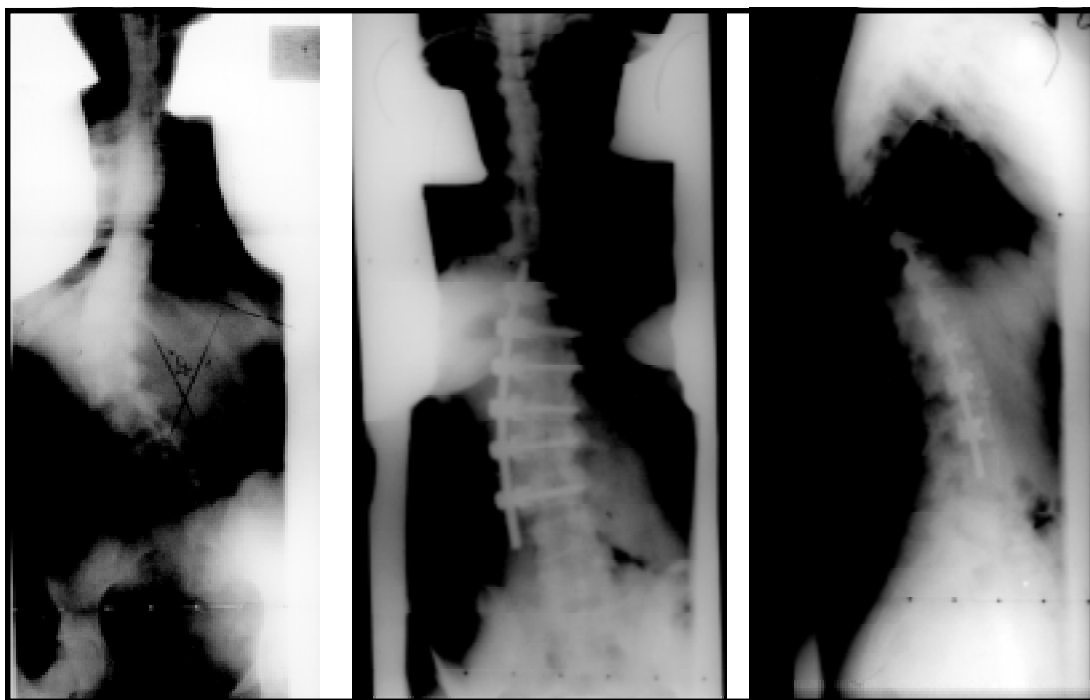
(Left). Pre-operative AP radiograph thoracolumbar spine. Figure 2 (Center). Post-operative AP radiograph thoracolumbar spine. Figure 3 (Right). Post-operative lateral radiograph thoracolumbar spine.
